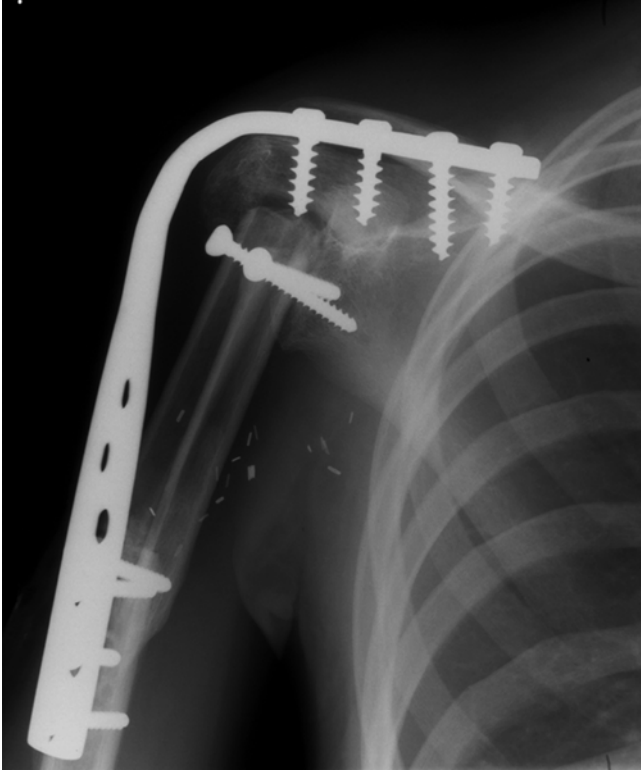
Radiograph of a reconstruction of the shoulder following an intraarticular resection of the proximal humerus for Ewings sarcoma. An arthrodesis was performed using a free vascularised fibular graft, and a contoured plate
